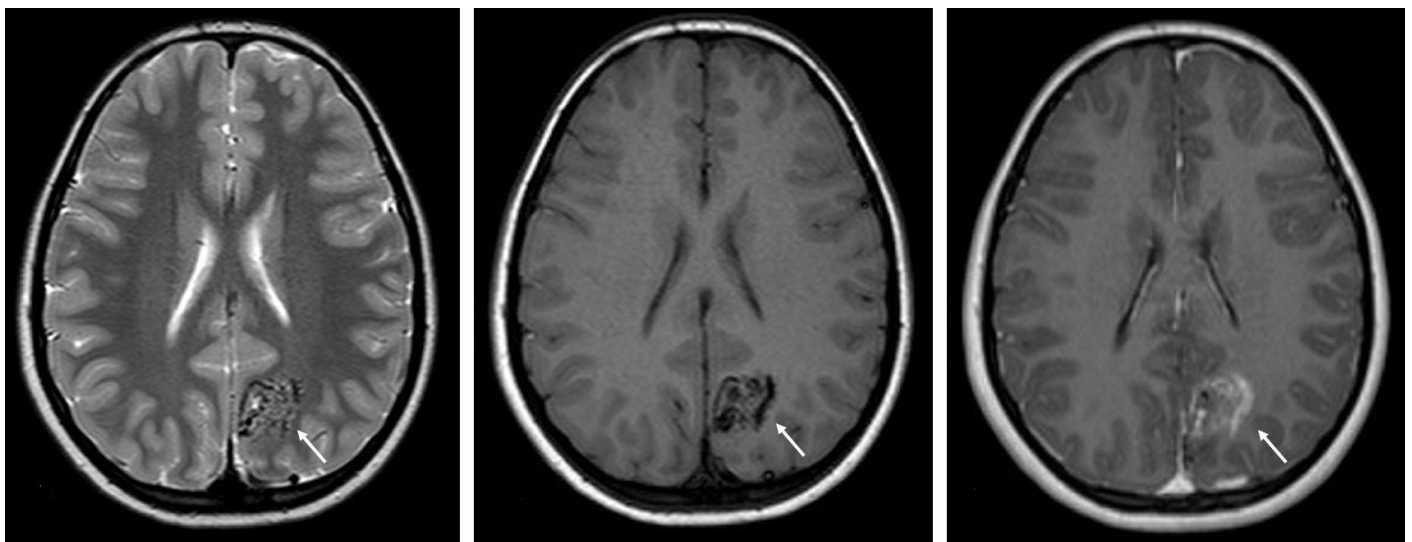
MRI of an eight-year-old female patient with epilepsy. The nidus of an arteriovenous malformation in the medial parafalcine region of the left posterior parietal lobe is seen in the cortico-subcortical area, consisting of enlarged and clustered signal-void vascular structures in axial T2-WI (on the left side), T1-WI (in the middle), which showed contrast enhancement after intravenous Gadolinium injection (on the right side).
